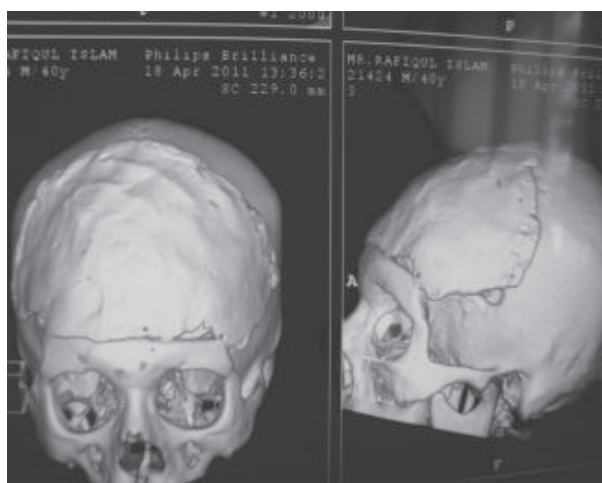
Bifrontal cranioplasty in CT brain with 3D reconstruction
